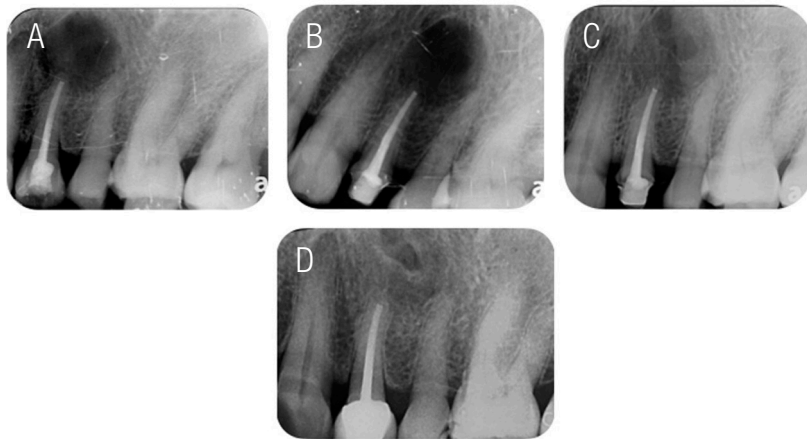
Periapical radiographs of the lesion. A. Lesion before surgery. B. Radiographic control of the lesion area at 6 months. C. Radiographic control of the lesion area at 1year. D. Radiographic control of the lesion at 4 years.
